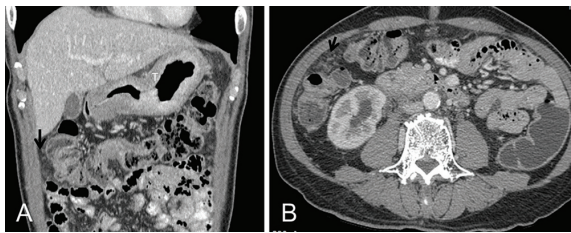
A) Coronal CT scan post contrast study shows diffuse thickening of gastric wall with abnormal transmural enhancement by infiltrative gastric tumor (T) at stomach, linitis plastica pattern. Focal increased peritoneal fat density at right side of omentum (arrow) is compatible with carcinomatosis peritonei. B) Axial CT post contrast study is also demonstrating the same peritoneal metastasis in right side abdomen. Note mild hydronephrosis of right kidney due to reteroperitoneal metastasis.
